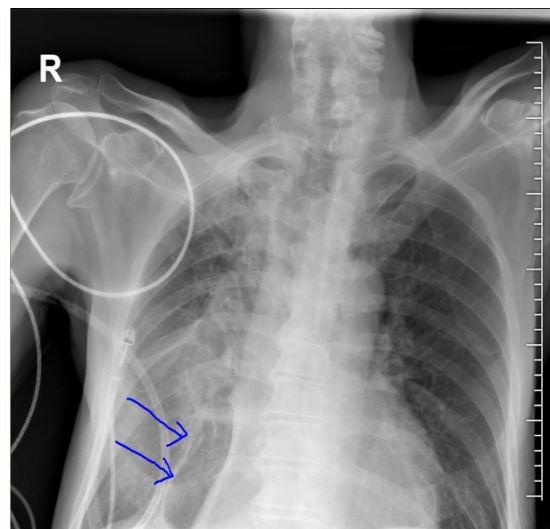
Chest X-ray (CXR).
